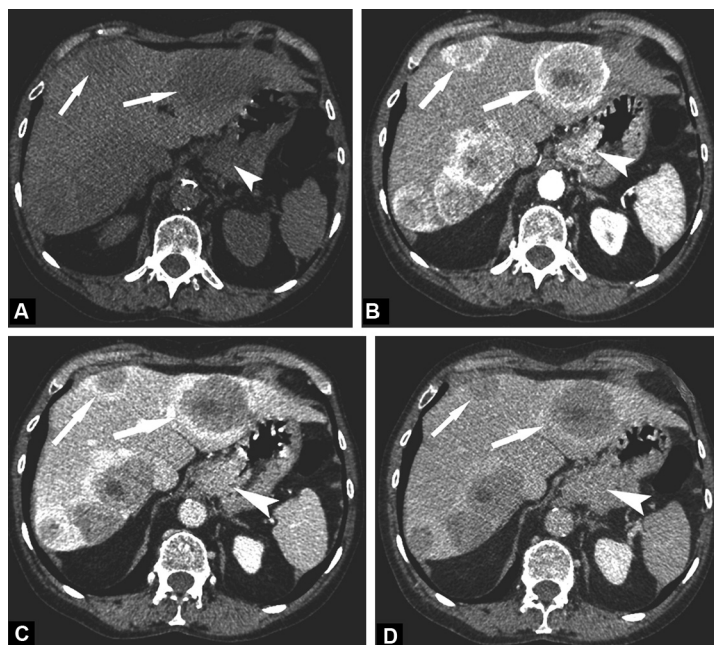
Computed tomography (CT) images of the abdomen in the transverse plane shows multiple liver lesions and asymmetric cardiac thickening. A. Before intravenous administration of iodinated contrast material CT shows hypoattenuating areas (arrows) and asymmetric thickening of the cardia (arrowhead). B. During the arterial phase (40 s) following administration of iodinated contrast material CT shows peripheral rim of enhancement of the liver lesions (arrows) and hyperenhancement of the cardiac thickening (arrowhead). C. During the portal phase (70 s), a decreased enhancement of the liver lesions (arrows) and cardiac thickening (arrowhead) is observed, with persisting peripheral rim of enhancement of the liver lesions. D. On the late phase (3 min), a wash-out phenomenon is observed within the liver lesions (arrows). The cardiac thickening becomes isoattenuating to the adjacent gastric wall (arrowhead).
